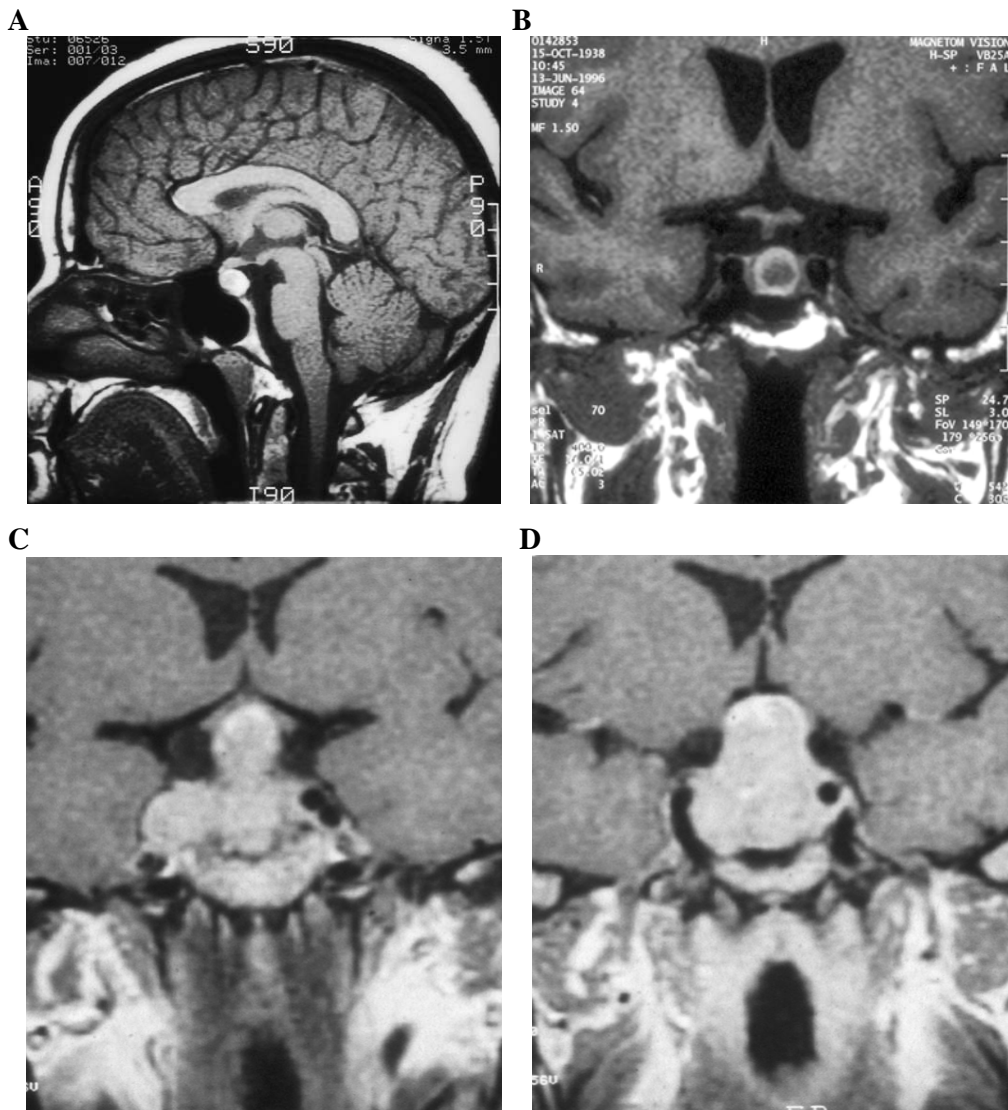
(A) Magnetic resonance imaging (MRI) scan of a classic case of lymphocytic hypophysitis in a 24-year-old woman who presented with symptoms of a pituitary tumor. Note the uniform enhancement with contrast with extension to the hypothalamus and (B) Coronal T1 weighted MRI scan of a 57-year-old man who presented with hypopituitarism and diabetes insipidus (DI) presumed to be due to lymphocytic hypophysitis. (From Crock et al. 2008) (213). (C and D) Coronal T1 weighted MRI with Gadolinium of a Non-functioning Pituitary Macroadenoma: Enhancement of the left-sided compressed pituitary and the non-infiltrated cavernous sinus; right cavernous sinus showing tumor invasion; optic chiasm is compressed dorsally from below (from personal surgical series of DK Ludecke, Hamburg University)
